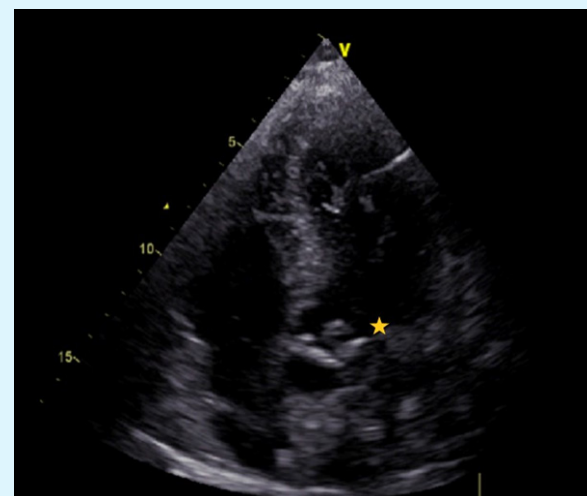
2D transthoracic echocardiography 4 chamber apical view. Asterisk showing a vegetation in ventricular side of a calcified aortic valve
